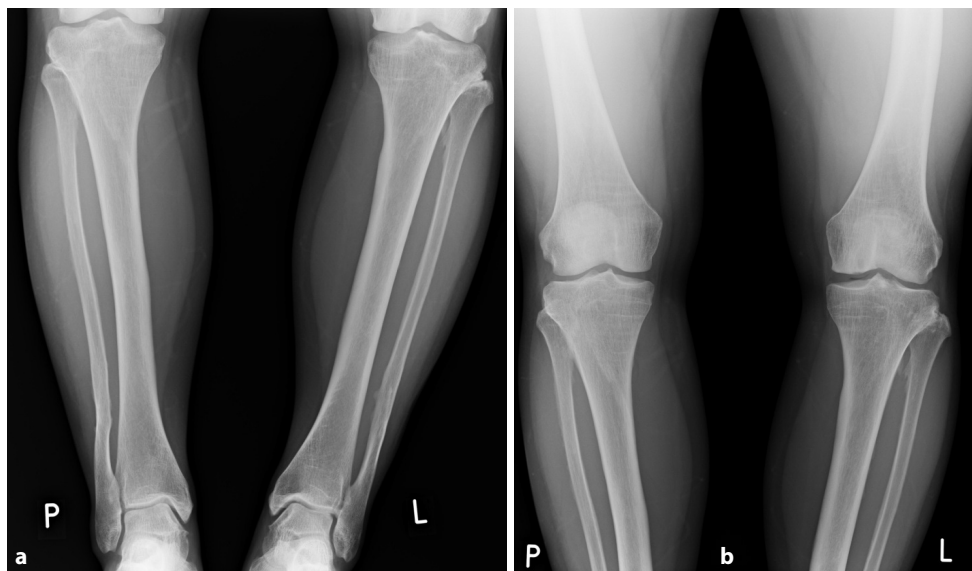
X-ray of both tibiae and knees in anteroposterior projection – 24 years old - before surgery: left tibio-femoral joint inclination is 8°; right articular slot is horizontal; varosity of the proximal dia-metaphysis of the left tibia is 5°; slight varosity in the distal 1/3 of the diaphysis of the femur bilaterally, more to the left. The articular slot of the talocrural joints are laterally varus – see a, more so on the left. Fine growth strips, so-called Harris lines, are shown on the condyles of both tibiae medially.
